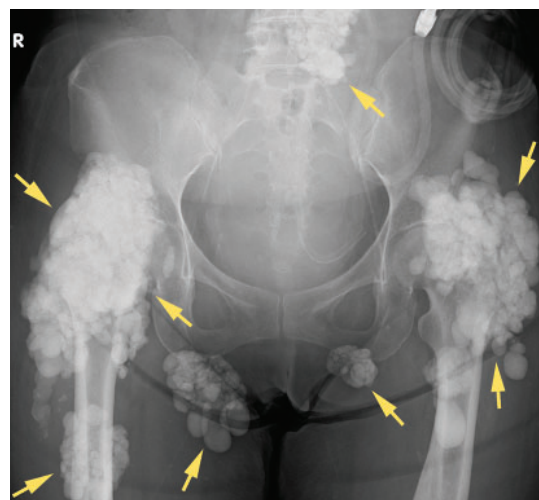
Pelvic radiography showed large, irregular, calcified masses (arrows) adjacent to the left lower lumbar spine, hip joints, and over both ischial tuberosities.
